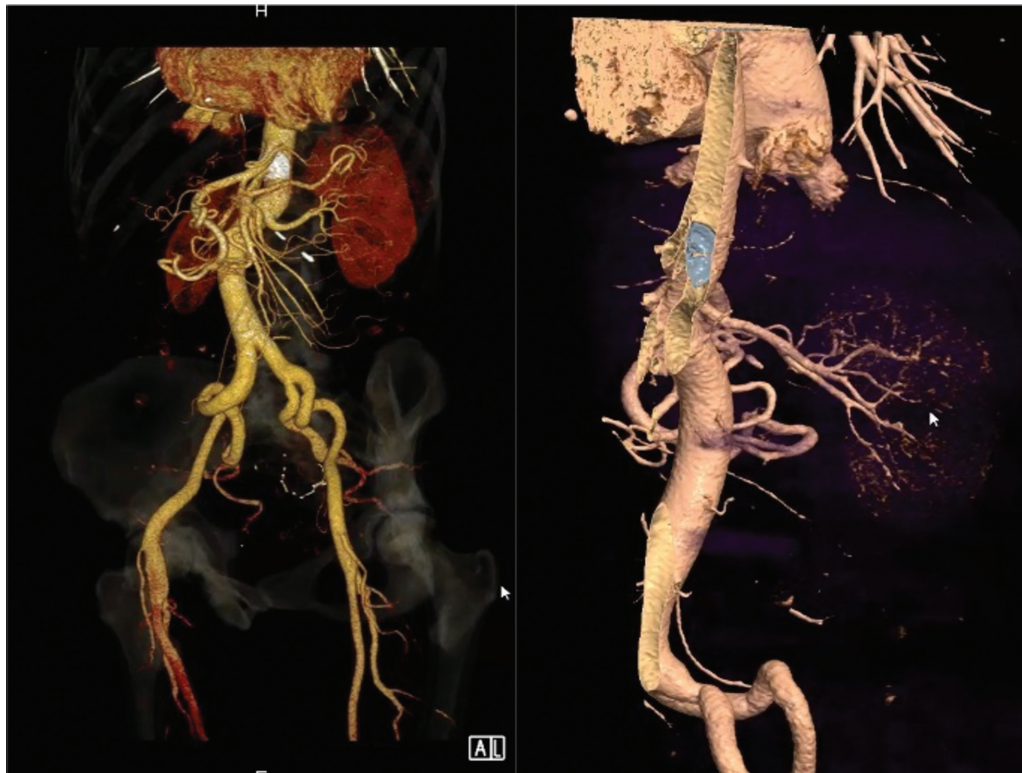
Digital reconstructions of computed tomography showing an important process of collateralization of the abdominal vessels after total occlusion of the superior mesenteric artery (the occluder is shown in white).
